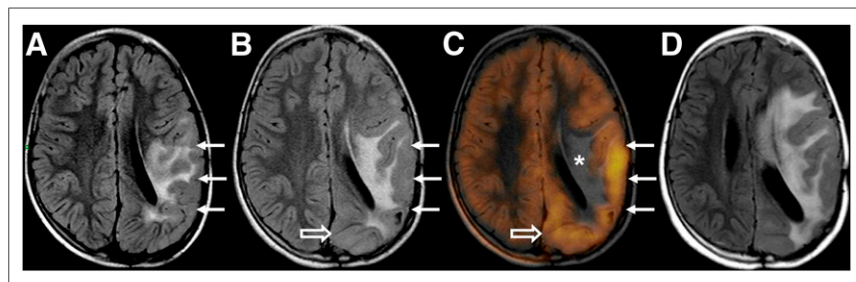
Anaplastic astrocytoma (WHO grade III). Differentiation between PD and treatment-related changes (case 6). Diffusely infiltrating lesion involving left frontoparietal region (thin arrows, A). MR imaging follow-up performed 3 mo after end of treatment (radiotherapy and temozolomide) revealed increased extension of FLAIR abnormalities, possibly representing edema or nonenhancing disease progression (open and thin arrows, B). There was no contrast enhancement on postcontrast MR imaging (not shown). ^{18}F -DOPA PET/MR imaging fusion (C) shows areas of moderately to markedly increased tracer uptake, in keeping with active disease. Notice absence of tracer uptake within areas of supposed vasogenic edema (*, C). Subsequent MR imaging (D) performed 2 mo later confirmed PD.
